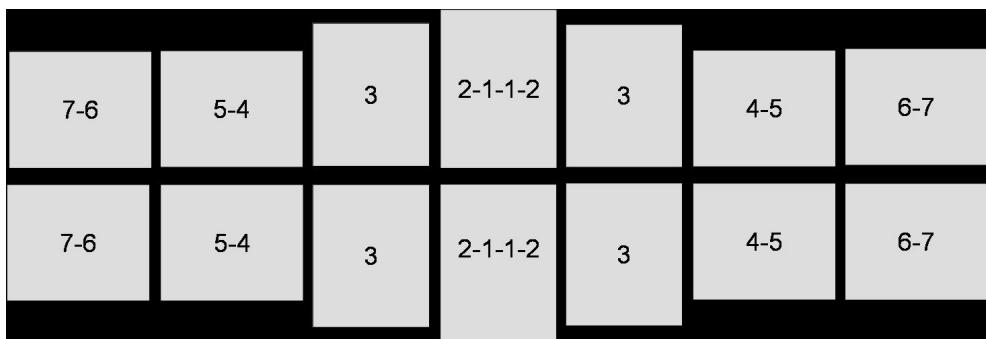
Periapical radiographic survey for adolescents.
